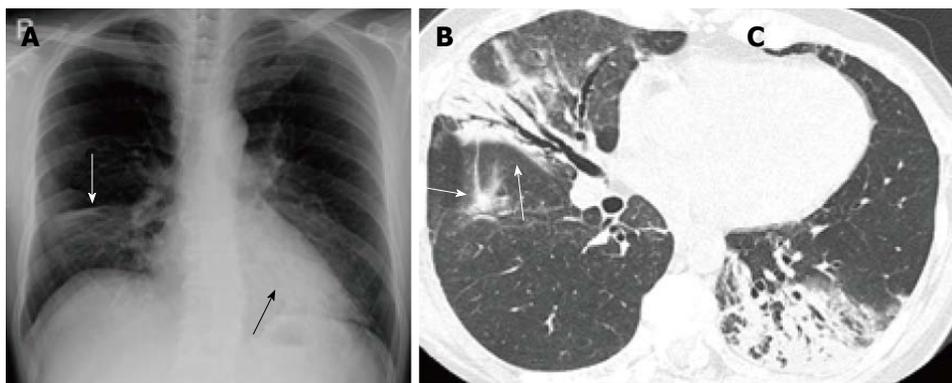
Cryptogenic organizing pneumonia in a woman in her 50s. A: Chest radiograph shows a consolidation in the right lower lung field with depression of the right minor fissure suggestive of volume loss of the middle lobe (white arrow). Retrocardiac consolidation is marginally seen (black arrow); B, C: Thin-section computed tomography of the right lung (B) and left lung (C) demonstrate consolidations with air bronchograms in both lungs. Note that the bronchi within the consolidations are mildly dilated and that the consolidations have concaved margins (arrows), suggesting organization of the disease.
